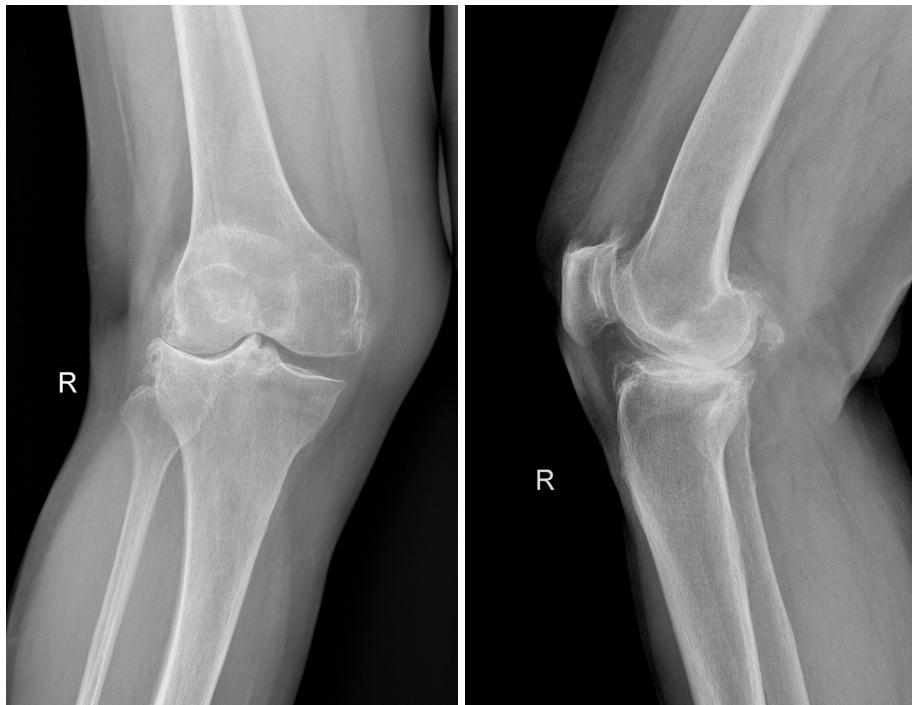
Pre-operative anteroposterior and lateral radiographs showing tricompartmental osteoarthritis with valgus deformity. R, right.
